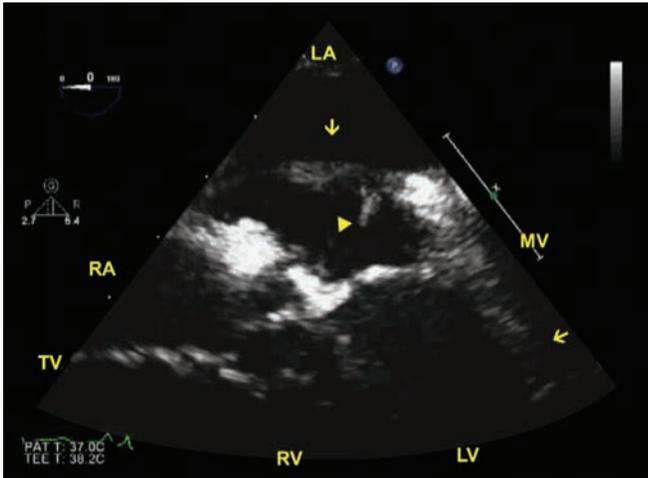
Transesophageal echocardiography. Arrow points to the lead. Arrowhead demonstrates the thrombus attached to the lead.
